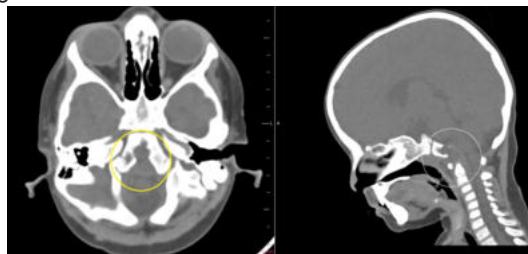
CT scan axial and sagittal images showing lytic lesion involving clivus
